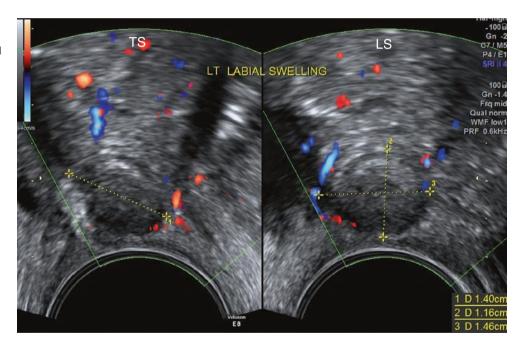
Bartholin gland cyst. A well-defined circumscribed mass seen just above and posterolateral to the vaginal introitus with turbid contents. It did not show any significant flow on Doppler and was not tender
